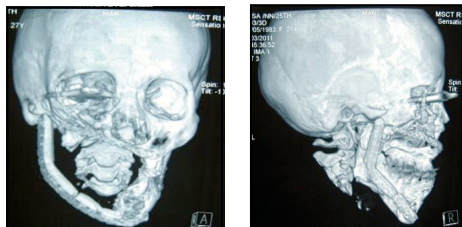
Post-operative CT Scan Images.
